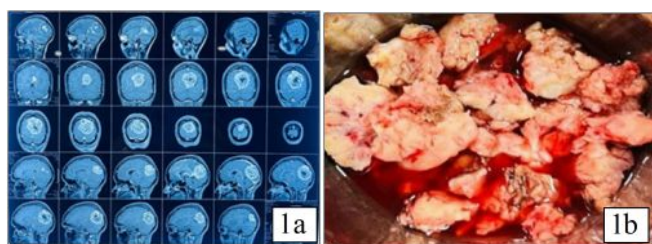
CE-MRI brain demonstrated a well-defined lobulated dural based lesion measures 5.9x 5.8x 6.4 cm.
